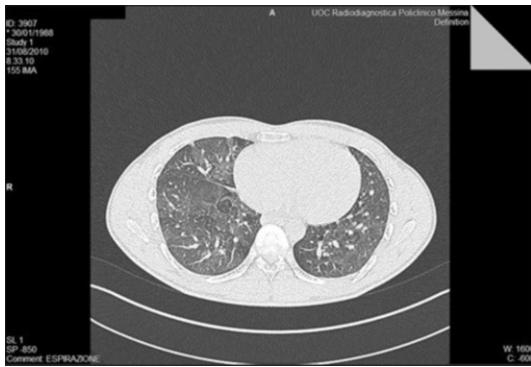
High resolution computed tomography (HRCT) lung at T1 shows some images of the mantle micronodular lung parenchyma, which do not increase in size than the previous examination. At the current appreciation we do not identify aspects frosted glass, or inter- and intralobular septal thickening, or clumps of inflammatory nature. We do not appreciate honeycombing, bronchiectasis or no bronchiolectasis traction. The density of lung parenchyma in breath is regular. It indicates only moderate diffuse abnormalities of the bronchial walls, which appear minimally thickened. This finding has not progressed from the previous examination.
